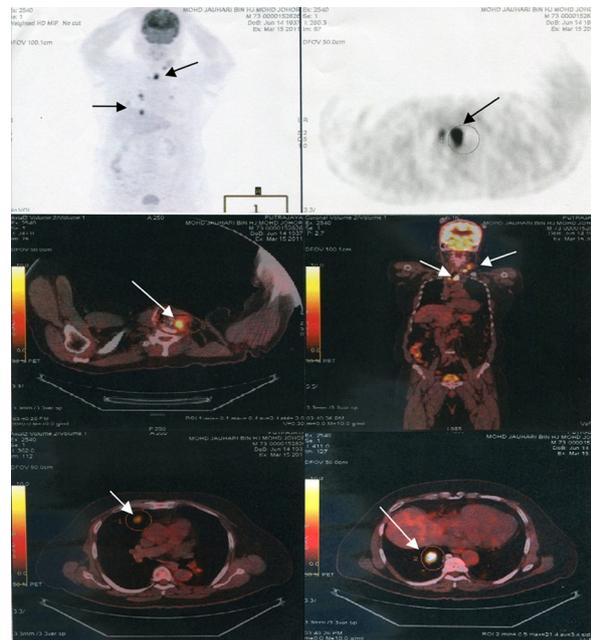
¹⁸F-FDG-PET/CT showed Foci of FDG hypermetabolism at left thyroid bed, left cervical lymph nodes and multiple lung nodules in the right lung (arrow) which was diagnosed as FDG avid local recurrence and metastases to lymph nodes in the neck and lung.
